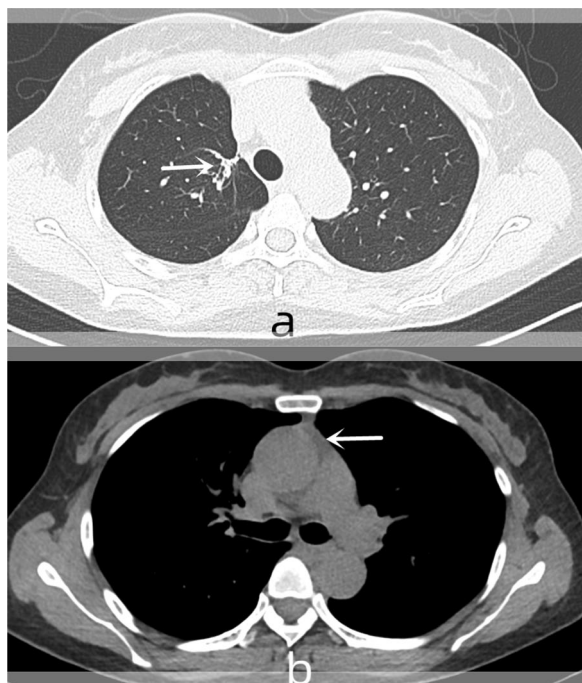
Chest CT scan 2 years after surgery. The arrow in a indicates the original surgical site of the lung, while the arrow in b indicates the original surgical site of the mediastinal tumor
